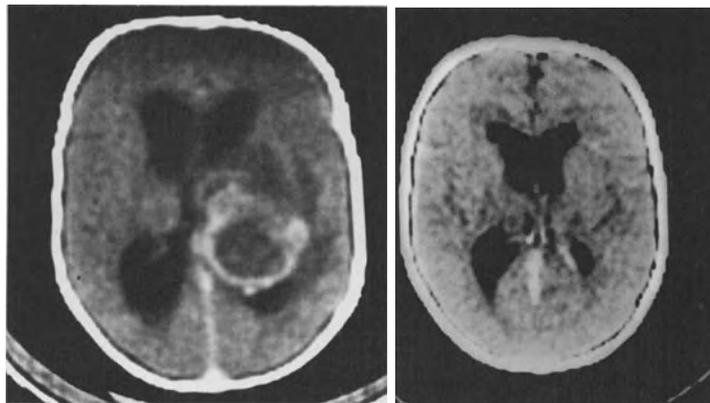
Patient No. 1 from Table 2 CT-scan, brain abscess parietal. *Left:* preoperative; *right:* post-aspiration
